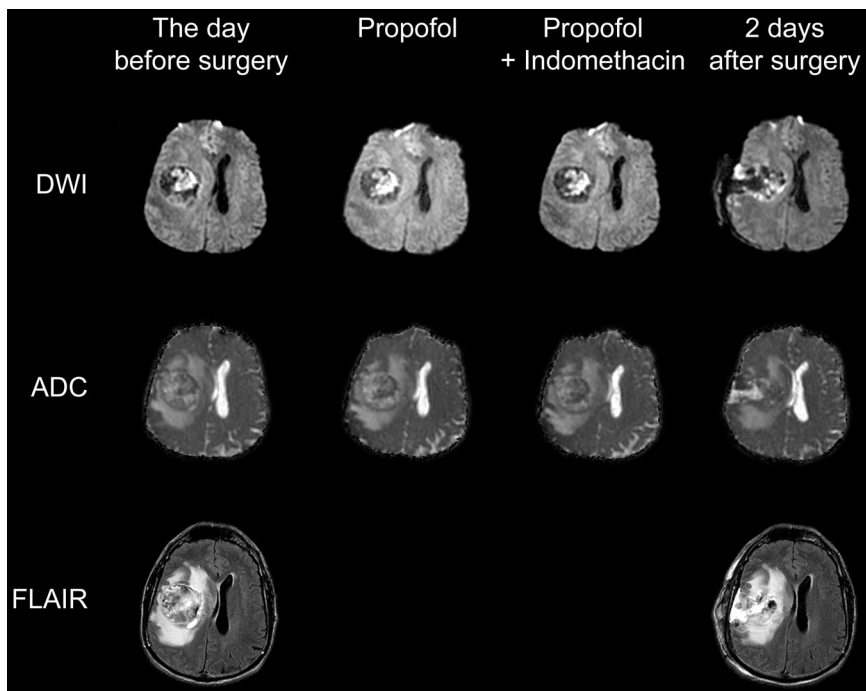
Magnetic resonance images of a 55-yr-old man with a gliosarcoma located in the right temporoparietal region. Diffusion-weighted imaging (DWI) sequences (top row) and apparent diffusion coefficient (ADC) maps (middle row) were obtained (1) on the day before surgery, (2) before and (3) 20 min after administration of indomethacin (bolus of 0.2 mg/kg followed by infusion of  $0.2 \text{ mg} \cdot \text{kg}^{-1} \cdot \text{h}^{-1}$ ) in the propofol-fentanyl-anesthetized patient, and (4) 2 days after surgery. Fluid attenuated inversion recovery (FLAIR) sequences (bottom row) were performed (1) on the day before surgery and (2) 2 days after surgery. Despite considerable mass effect of the tumor, DWI and FLAIR images revealed no ischemic tissue damage. The finger-shaped surgical cavity appears *black* on DWI and *white* on ADC pictures in the last column (2 days after surgery). The area in the right frontal operculum just anterior to the surgical cavity, which appears *white* on DWI and *black* on ADC images, represents a small cortical lesion during the partial tumor resection.
